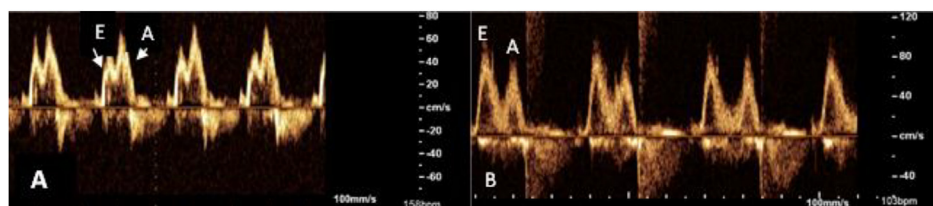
Mitral valve inflow Doppler. A. Normal E/A ratio in a 7 day old preterm neonate with a larger atrial kick component of ventricular filling (A wave), compared with initial passive filling (E wave) B. Normal E/A ratio in a 10 month old infant, with majority of left ventricular filling occurring passively during initial opening of the valve (E wave).
